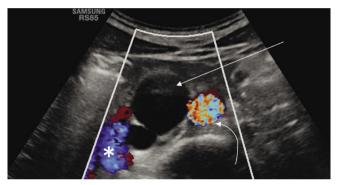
Color Doppler image shows no signal in cisterna chyli (straight arrow), located between the abdominal aorta (curved arrow) and inferior vena cava (asterisk)
